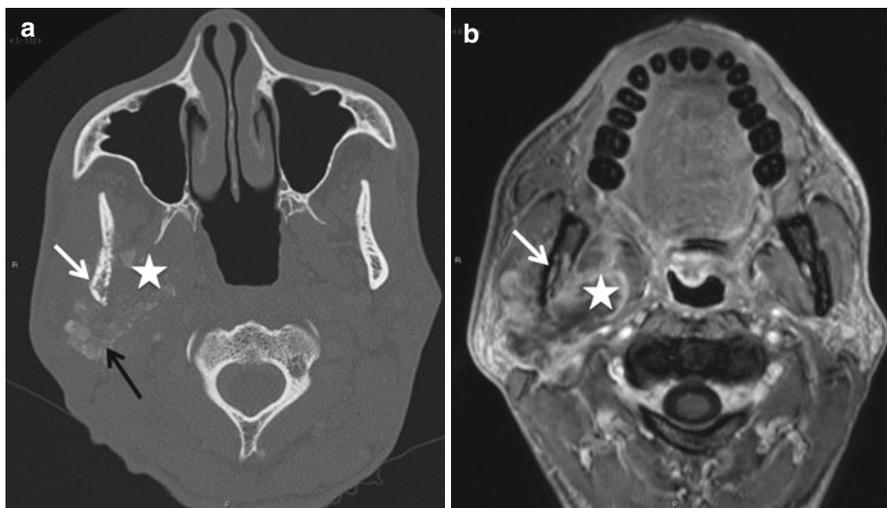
Mandibular osteosarcoma. Axial CT (a) and post-contrast MR (b) show a heterogeneous aggressive tumor within the right masticator space arising from the right mandible (*white arrow*). Note the large soft tissue component of the tumor completely effacing the right parapharyngeal space along with new bone formation on the CT (*black arrow* in a) (*white star* in a and b)
